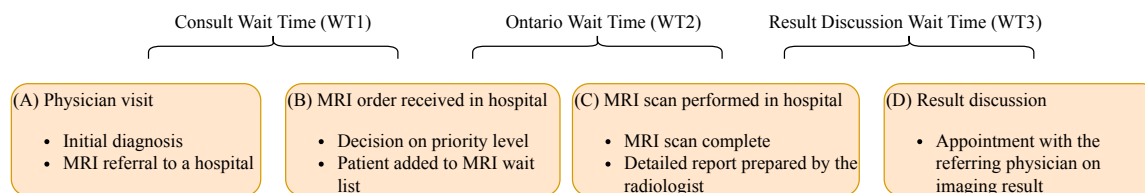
Timeline for patients in need of MRI scans
